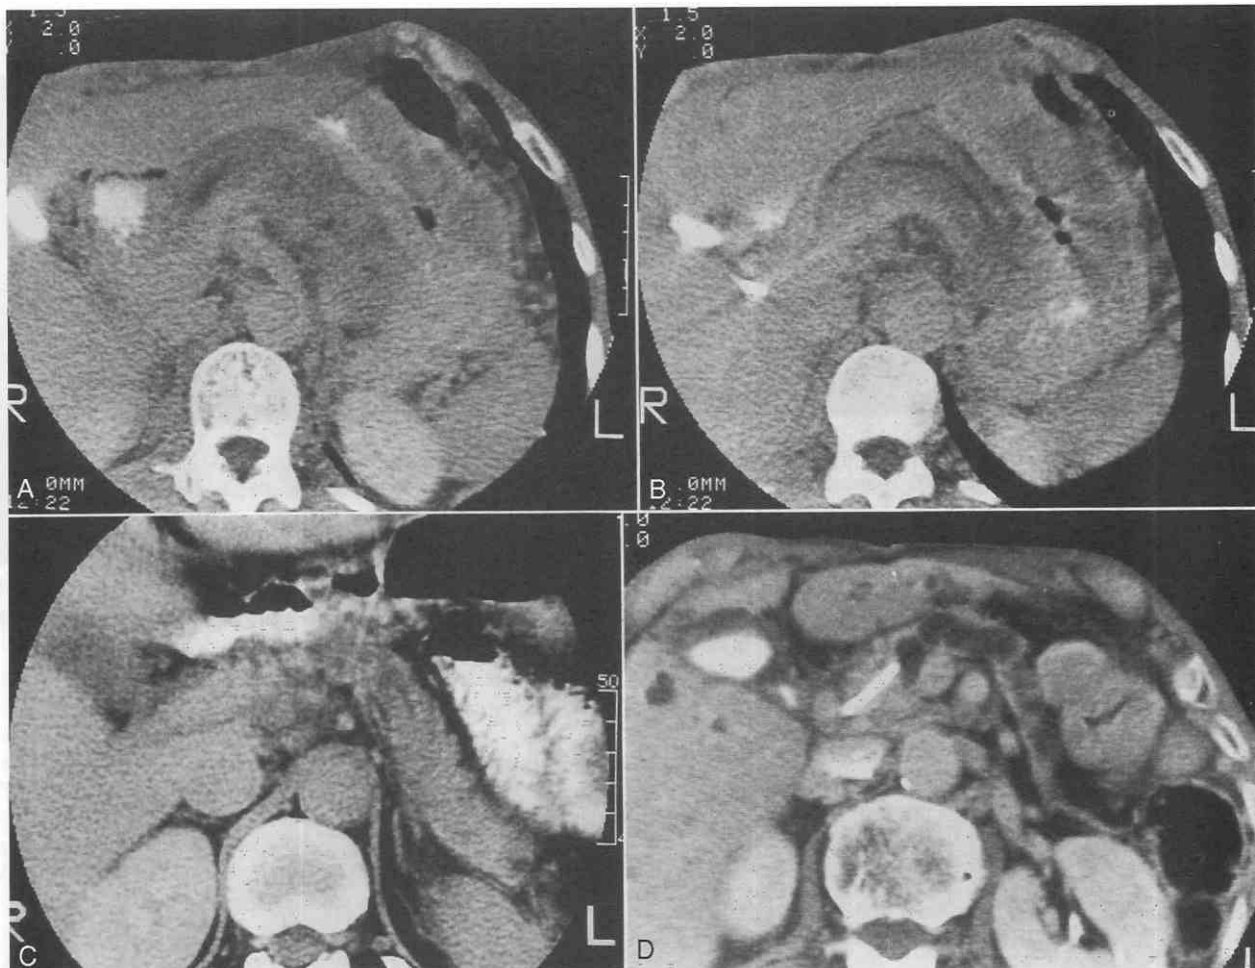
Sequential changes in the pancreatic body on CT in patients with pancreatic head carcinoma. This patient was followed clinically because of poor respiratory function. Carcinoma was confirmed by postmortem examination. *A*, Initial CT scan shows marked enlargement of the pancreatic body. *B*, Two months later, the width of the pancreatic body is decreased, and a smooth, narrow pancreatic duct is seen continuously. *C*, Four months later, the pancreatic body has become normal in size. *D*, Atrophy of the pancreatic body and marked dilatation of the pancreatic duct with a beaded contour are demonstrated 7 months later. (From Muranaka T: Morphologic changes in the body of the pancreas secondary to a mass in the pancreatic head: Analysis by CT. *Acta Radiol* 31:483-488, 1990.)
